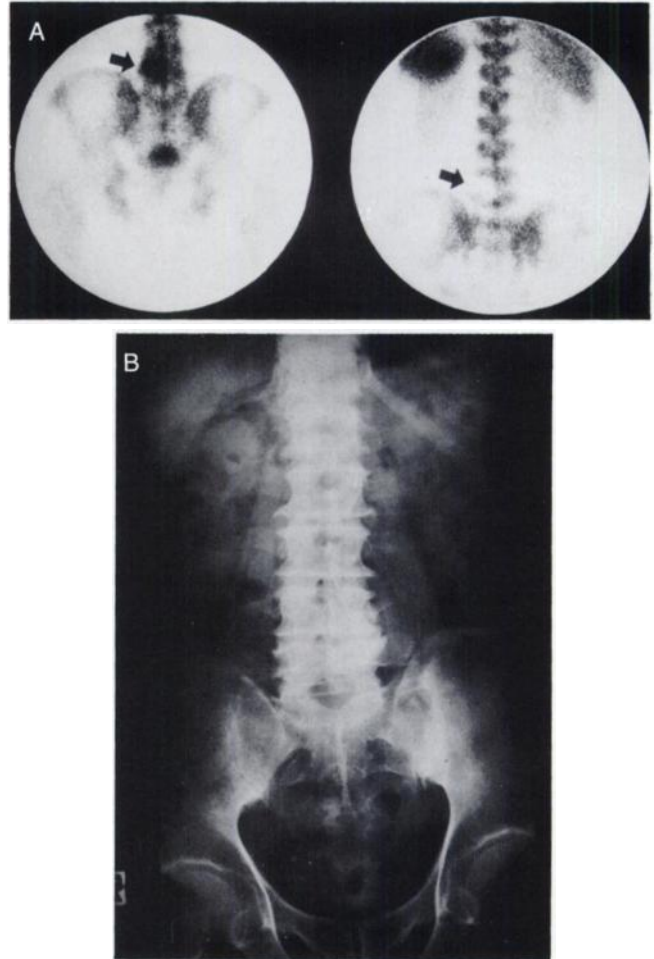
(A) AGA scan in a patient with bladder cancer shows a focal marrow defect in the fifth lumbar spine (right) concordant with the bone scan lesion (left). (B) Simple radiograph shows that the lesion was caused by degenerative disease of the spine.
